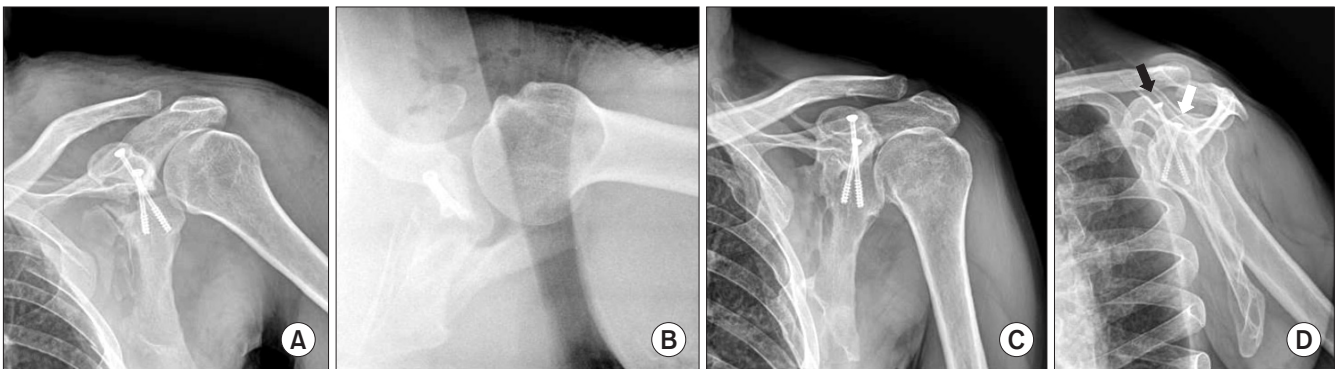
(A) Immediate postoperative left shoulder anteroposterior radiograph showing anatomic fixation of a transverse glenoid fracture with two partially threaded cannulated screws, placed perpendicular to the fracture surface. (B) Immediate postoperative axillary view confirmed that the two screws were fixed in proper divergent direction. There was no evidence of intra-articular invasion of the joint by the hardware. (C) Anteroposterior view of the left shoulder 25 months postoperatively showing a well healed fracture with acceptable alignment. (D) Lateral view of the left scapular showing screws placed 35 degrees divergent in the coronal plane. The white arrow indicates the screw through the Neviaser portal and the black arrow indicates the screw through the base of the coracoid process.
